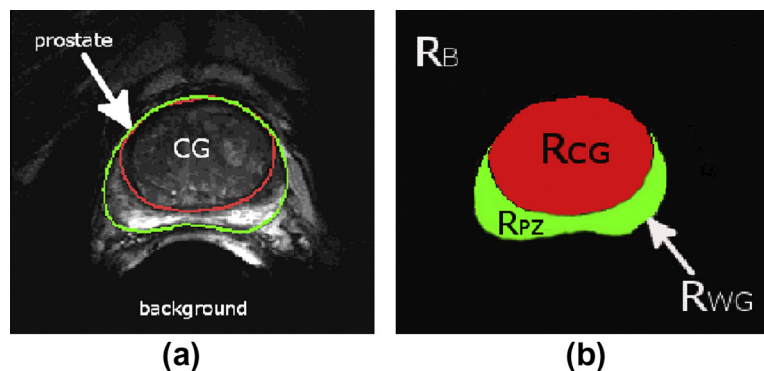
Contours overlaid on a T2w prostate MRI slice (a) and proposed layout of anatomically consistent regions (b). The prostate region \mathcal{R}_B is divided into two sub-regions: central gland \mathcal{R}_{CG} and peripheral zone \mathcal{R}_{PZ} and is mutually distinct from the background \mathcal{R}_B .
